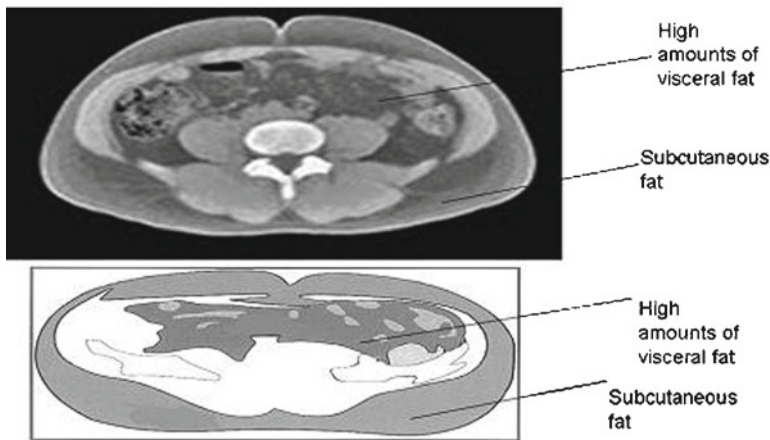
This CT scan image shows the distribution of abdominal fat in an obese individual. The visceral fat area is regarded as black colour and the subcutaneous fat area is regarded as grey colour.
